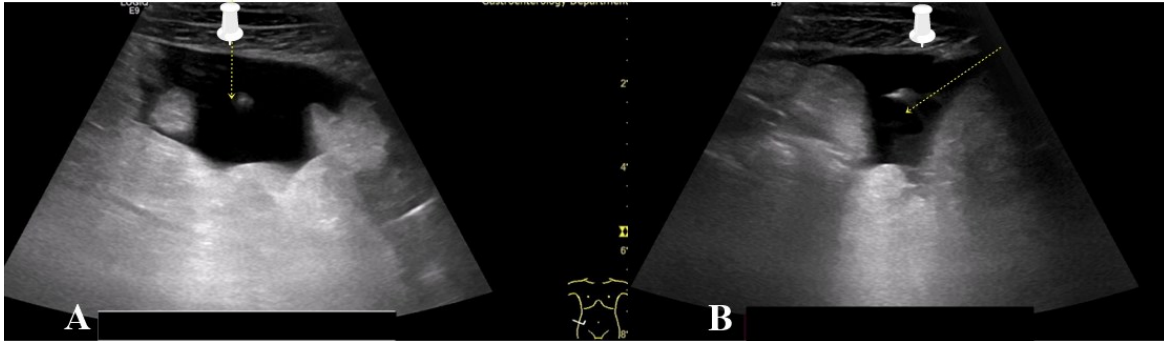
(A) Ultrasound-guided aspiration, showing only the needle tip due to the "out-of-plane" approach (dotted arrow indicating the direction of the needle). (B) "In-plane" approach, allowing full visualization of the needle trajectory, enabling better control and accuracy.
